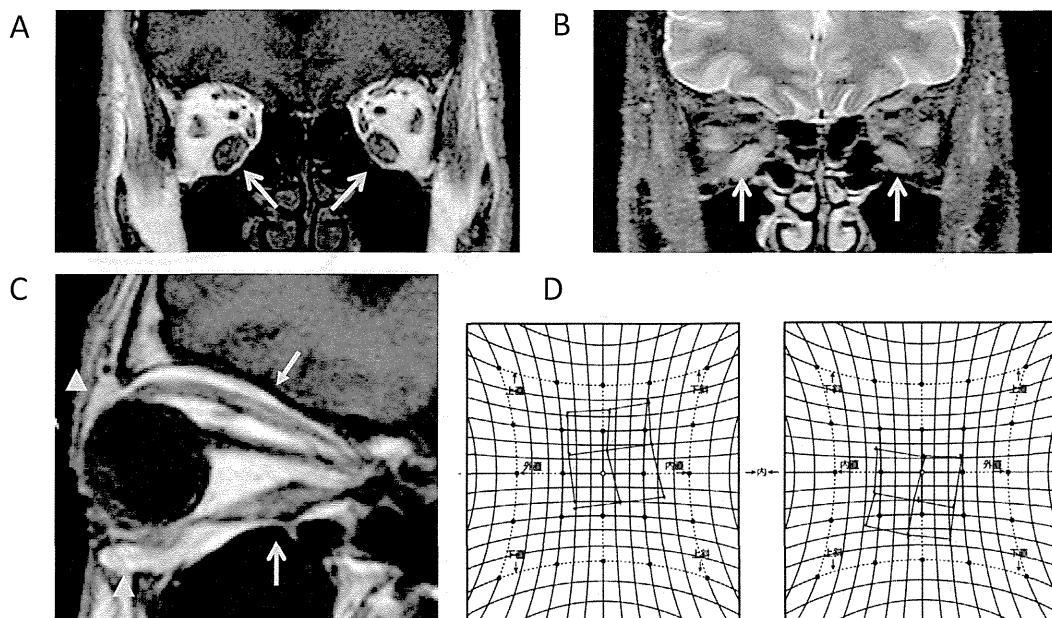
A 73-year-old man with Graves' disease visited our clinic with diplopia upon an upward gaze. He had conjunctival injection and proptosis (right: 22 mm, left: 19 mm) with eye muscle dysfunction. Orbital MRI showed enlargement of the bilateral inferior rectus muscles (arrows) and fat tissue accumulation in the eyelids (\blacktriangle). A: T1-weighted image in a coronal section. B: Short inversion time inversion recovery (STIR) image showing high intensity with enlarged inferior rectus muscles. C: T1-weighted image in a sagittal section. D: Hess chart showing the presence of extraocular muscle dysfunction. The clinical activity score was 1. The NOSPECS class was II_a, III_c, IV_b, V₀, VI₀.
